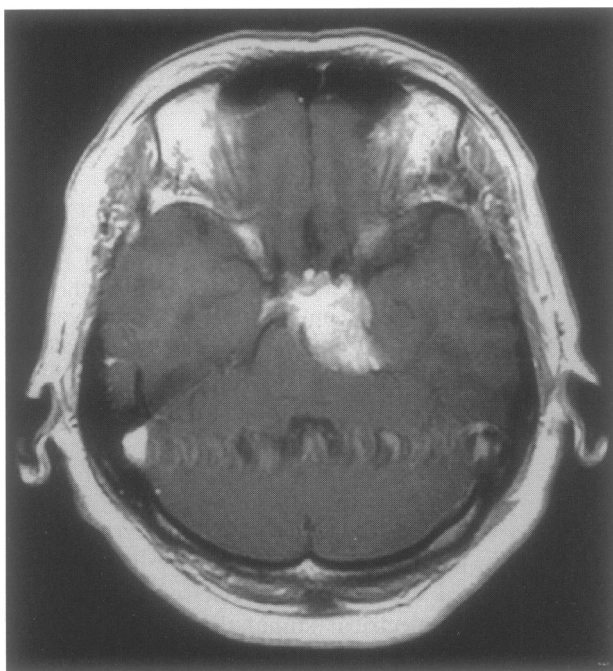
Preoperative MRI in Case 2, revealing an enhanced mass lesion in the left petroclival region.
